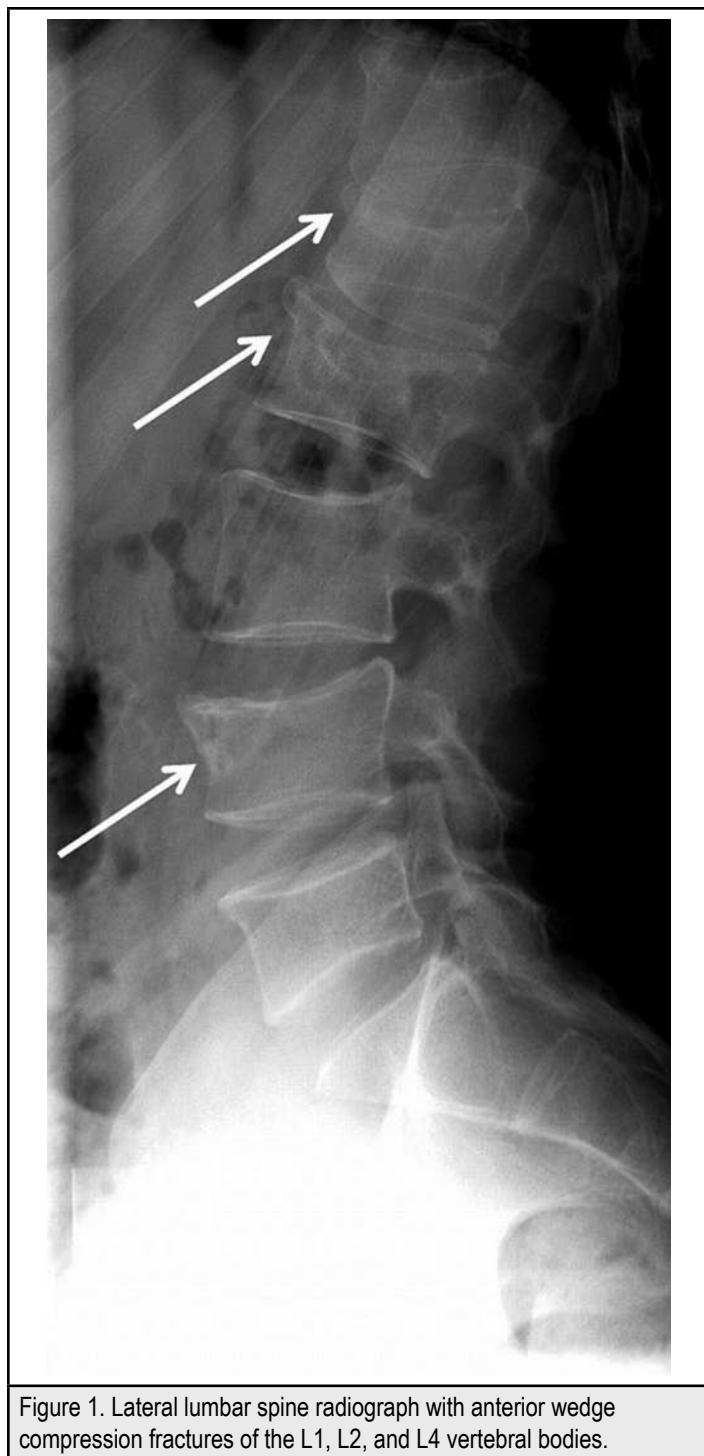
Lateral lumbar spine radiograph with anterior wedge compression fractures of the L1, L2, and L4 vertebral bodies.
